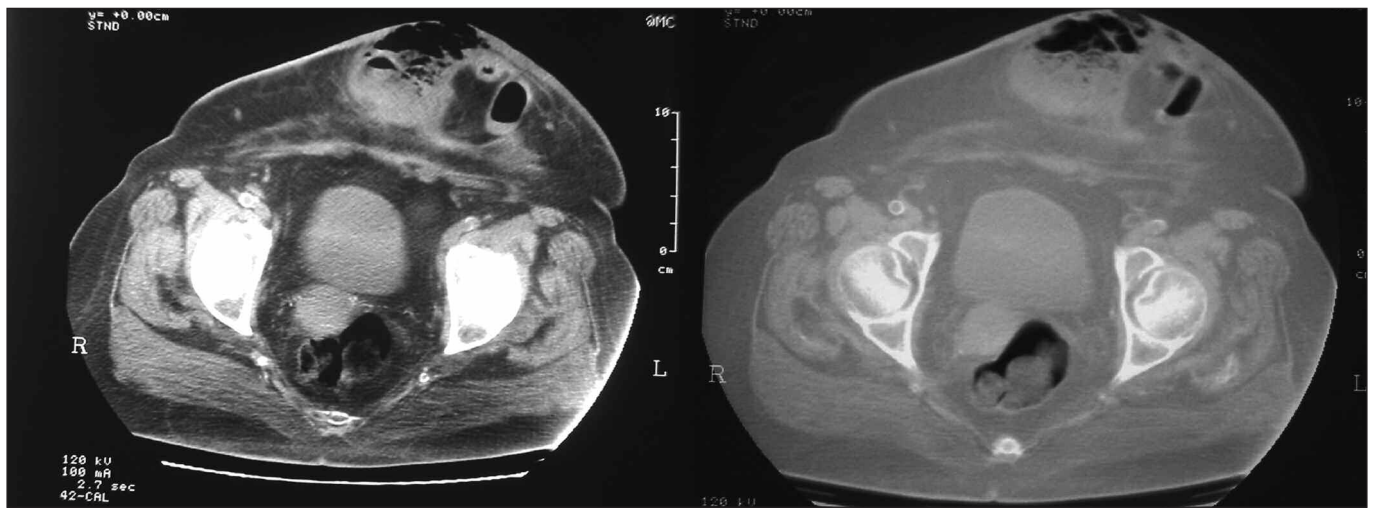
Abdominal CT images: Left (abdominal CT with IV contrast). Right (abdominal CT with pulmonary window to identify intraperitoneal gas). A large umbilical hernia may be seen that includes grossly thickened small-bowel loops with accessory collection; the hernia itself seems to have no continuity with the outside.
